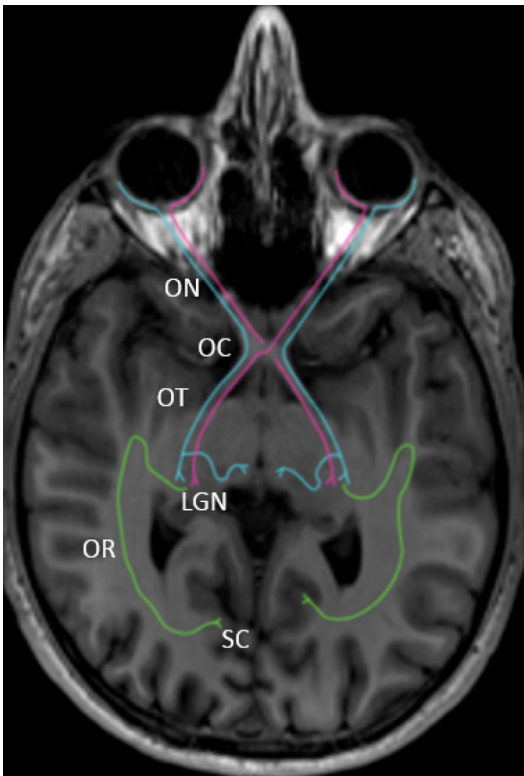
Afferent visual pathways. Lines are drawn superimposed on an axial T1-weighted image showing expected location of the optic nerves (ON), optic chiasm (OC), optic tract (OT), lateral geniculate nucleus (LGN), optic radiation (OR), and striate cortex (SC).
